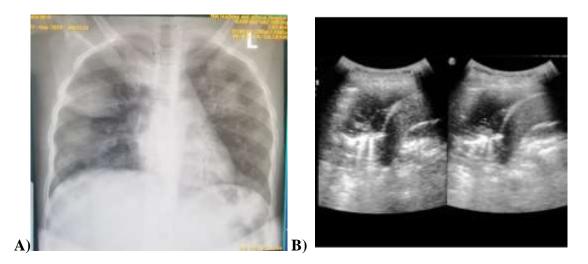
CXR and LUS. A 10-year-old female patient who presented with clinical diagnosis of pneumonia. A; Chest x-ray showing right and left upper lobe consolidation. B; lung ultrasound showing lung consolidation.
